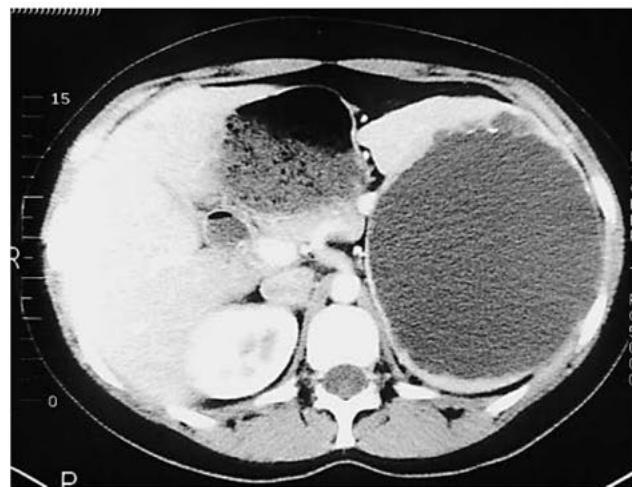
Abdominal CT scan showing a 16-cm posterior splenic epidermoid cyst. Open partial resection because of suspected echinococcus cyst.
